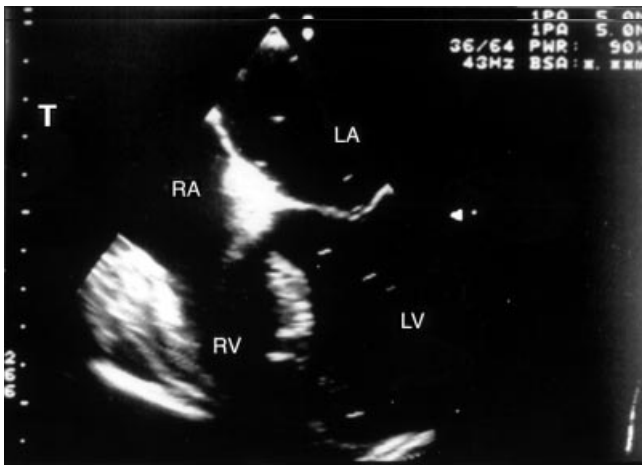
Four-chamber view transoesophageal echocardiogram showing the right atrium (RA), left atrium (LA), right ventricle (RV) and left ventricle (LV). About 15 min after the reduction of end-tidal CO_2 , air bubbles were seen continuously only in the LA and LV. There were no air bubbles within the right heart.
